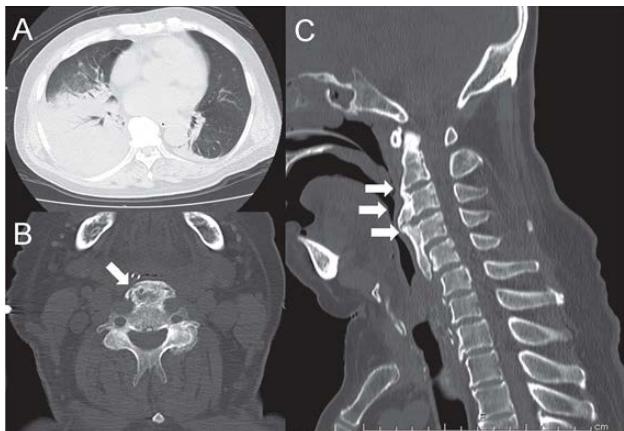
Chest computed tomography showing aspiration pneumonia. B: Cervical axial CT at C4 level demonstrated OALL. C: Cervical sagittal CT noted osteophytic spurs in the anterior aspect of the C2-5 vertebrae (white arrow), in close approximation to the inlet of the esophagus.
